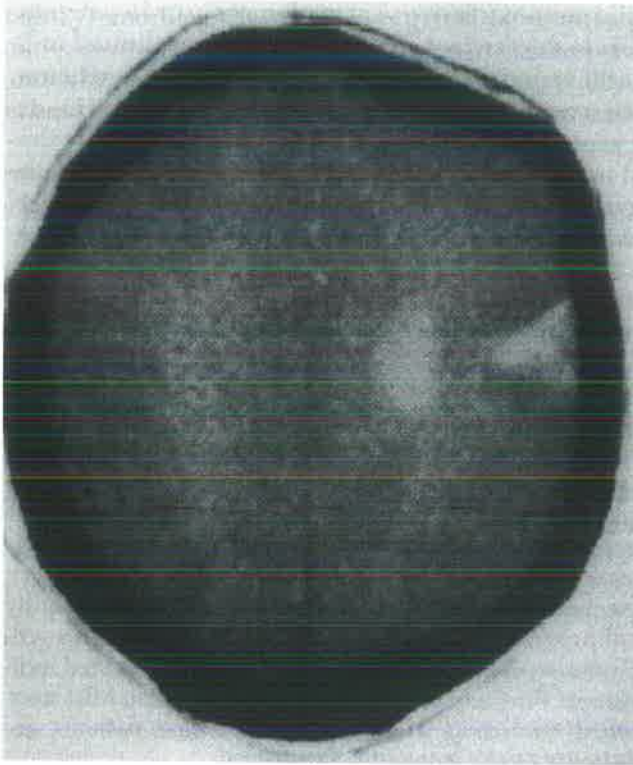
Computed tomographic scan showing schizencephaly in a patient with Crouzon's syndrome.*
